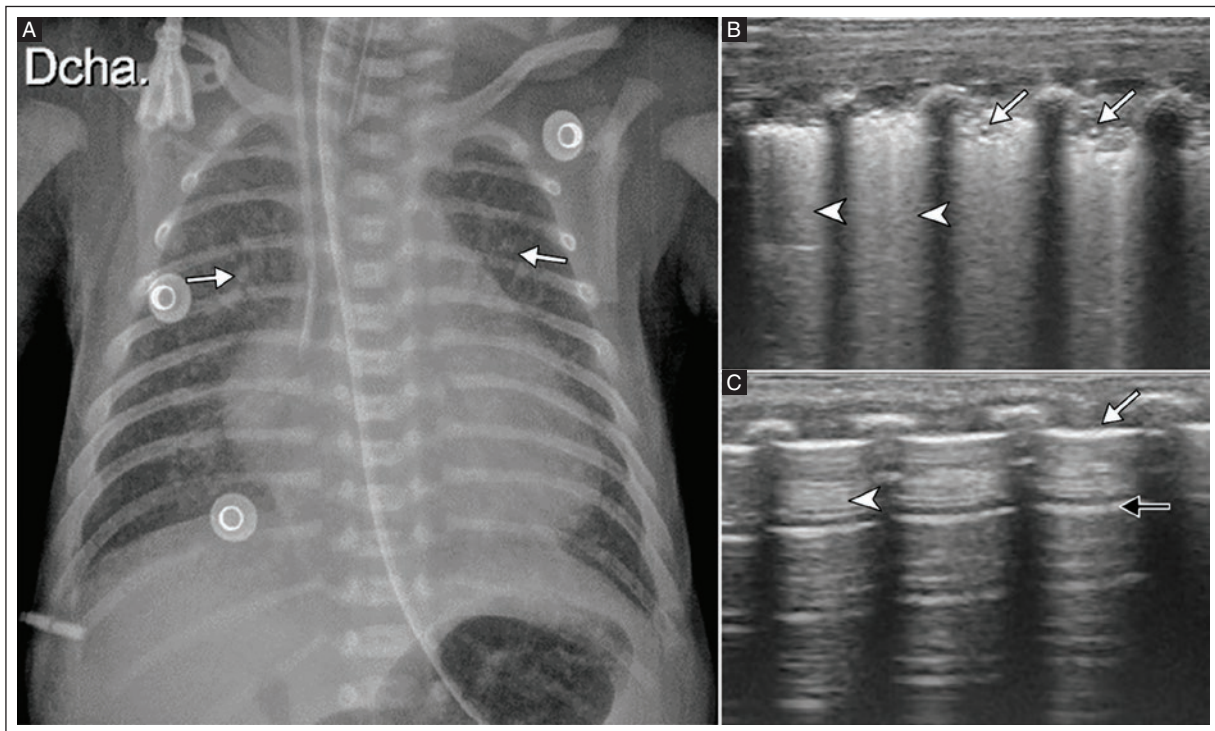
Male preterm neonate born by cesarean section at 30 weeks gestation with 24 hours of extrauterine life with an NRD requiring endotracheal ventilation. A: AP chest x-ray shows diffuse bilateral alveolar opacities (white arrows). An endotracheal tube, feeding tube, and central venous catheter are seen with the catheter tip projecting at the cavoatrial junction. B: lung POCUS of the left posterior-inferior quadrant shows loss of normal pleural line morphology and echogenicity due to subpleural focal atelectasis (white arrows) and an increased number of B-lines forming a “white lung pattern” (white arrowheads). C: lung POCUS of the right posterior-inferior quadrant shows a pleural line with normal echogenicity and thickness (white arrow), the presence of B-lines (white arrowhead), and preserved A-lines with a normal appearance (black arrow). The diagnosis was subpleural atelectasis on chest X-ray and shortened lung POCUS.
